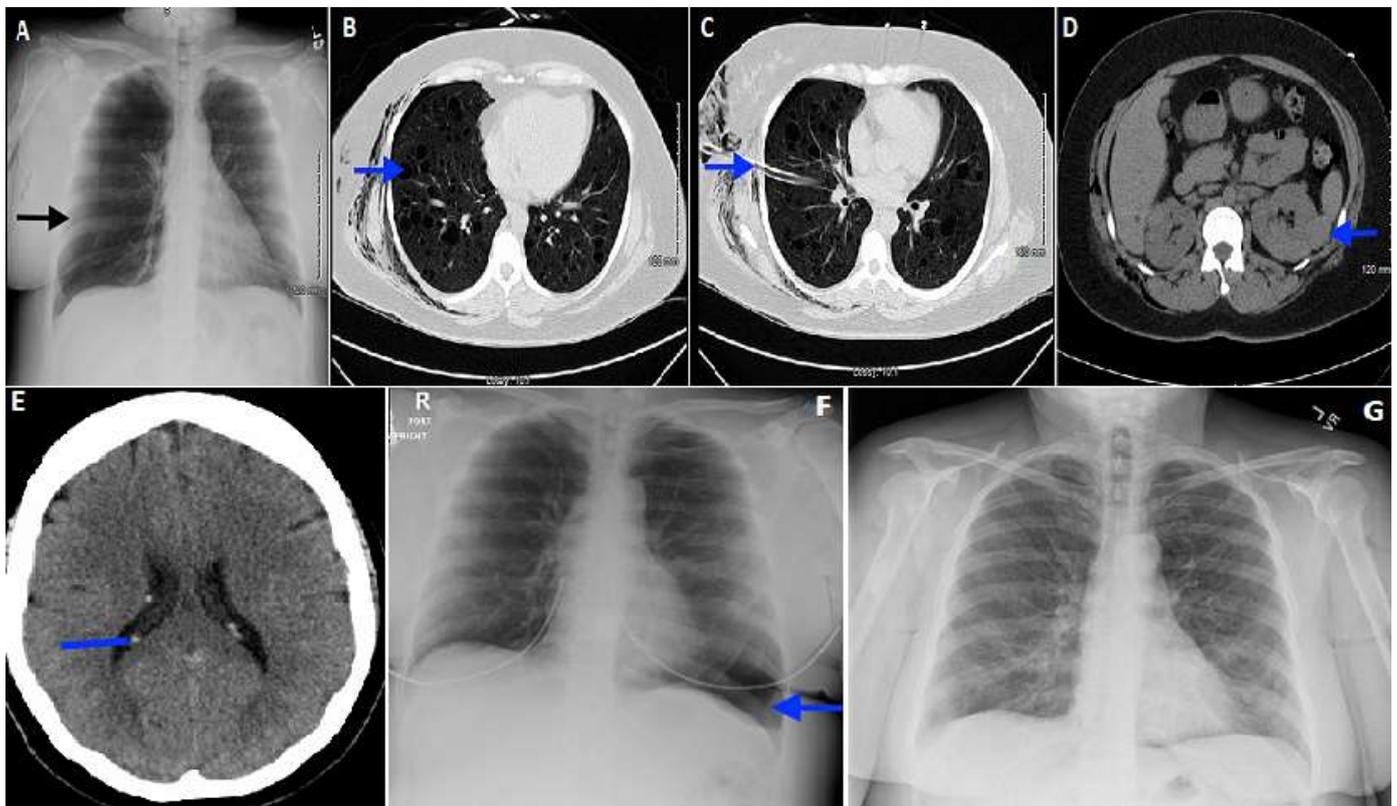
A) chest X-ray showing large right sided pneumothorax (arrow); B) CT chest without contrast showing innumerable cysts in bilateral lungs (arrow showing one of the cysts); C) CT chest without contrast showing right thoracostomy tube (arrow); D) CT abdomen showing hyperdense mass in left (arrow); E) CT head without contrast showing small calcifications in the lateral ventricles suggestive of tubers (arrow); F) chest X-ray showing left sided pneumothorax at lung base comprising approximately 30% of the thoracic volume; G) chest X-ray showing interval resolution of the left sided pneumothorax
